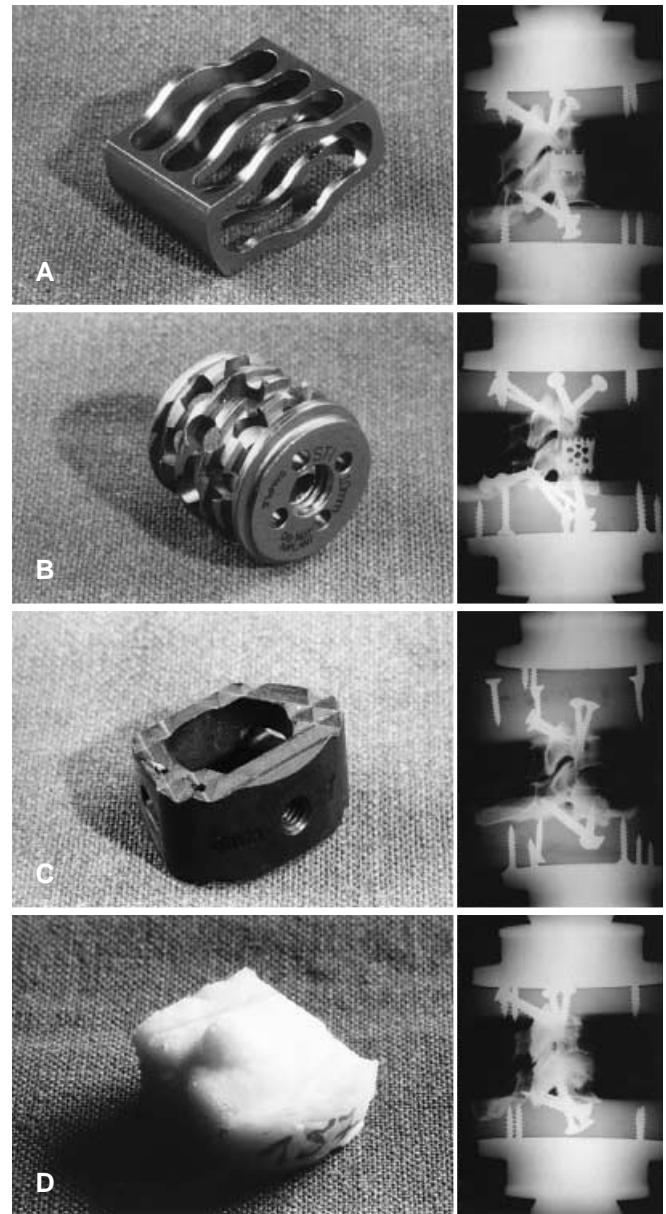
A–D Photographs (*left*) and plain lateral radiographs (*right*) of the three anterior cervical fusion cages and bone cement. A WING cage (Medinorm AG, Quierschied/Saar, Germany), B BAK/C cage (Spinetech, Minneapolis, USA), C AcroMed I/F cage (DePuy AcroMed International, Leeds, UK), and D bone cement dowel, explanted after testing (Duracem, Sulzer Medica, Winterthur, Switzerland)
